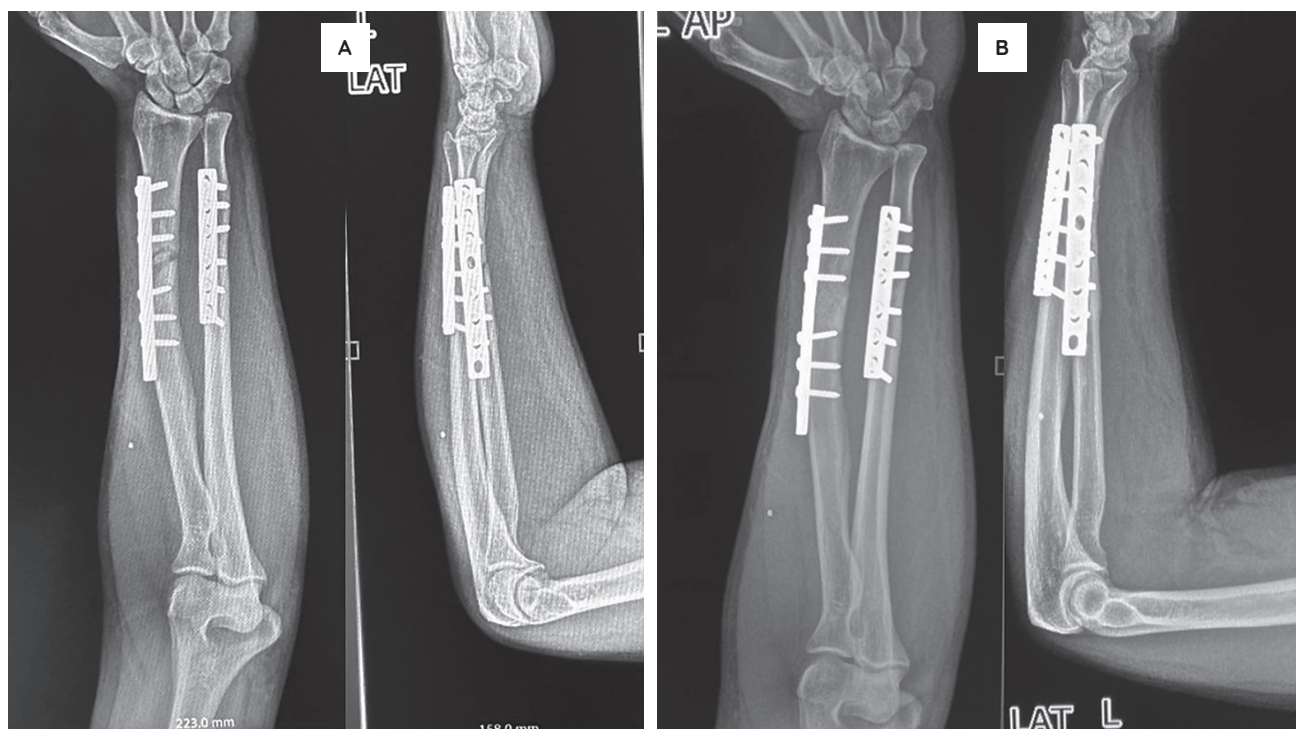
A 41-year-old male diagnosed with oligotrophic nonunion of the radius 6 months post-operatively. Pre-PRP Radiograph (A) reveals no callus formation. Post-PRP Radiograph after 6 months (B) reveals absence of fracture line and recanalization.
